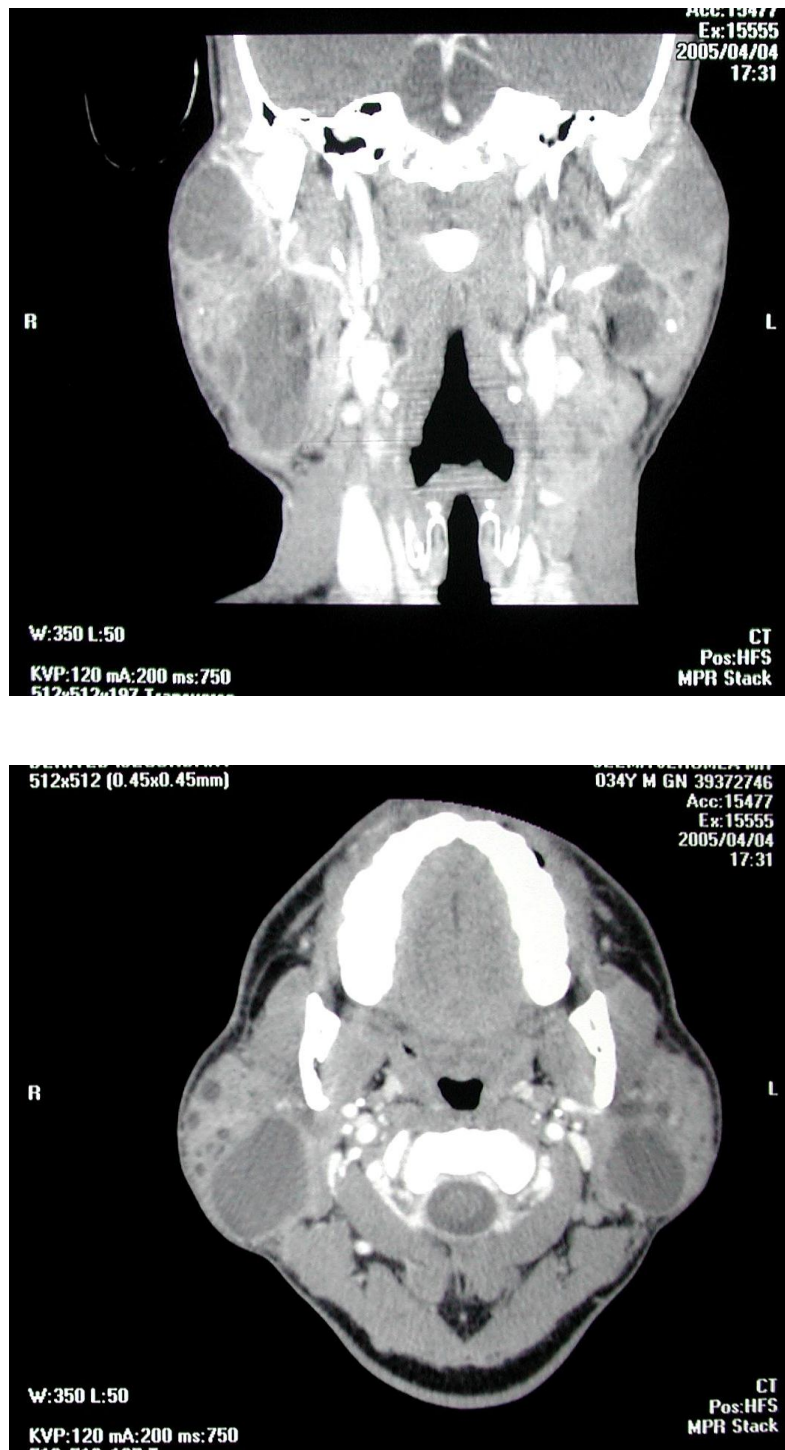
CT scans coronal (A) and axial (B) views showing multiple, oval, variably sized radiolucencies present bilaterally within abnormally dense parotid glands
